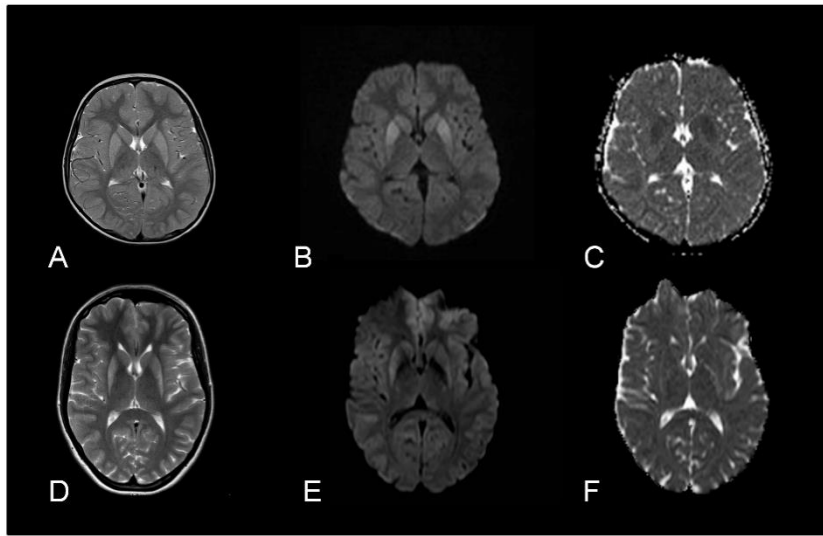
MRI features associated with dominant PDE10A mutations. Axial MR images of case 1 (A-C) and 2 (D-F). There is increased signal intensity within the striatum on T2-weighted images (A, D) and diffusion-weighted images (DWI) (B, E). In case 1, the putamen and caudate nucleus appear slightly swollen (A) and high signal on DWI (B) is confirmed to represent abnormal restricted diffusion on the ADC map (C). In case 2, the abnormal signal is principally located in the postero-lateral putamina, which also appear atrophic (D). There is no corresponding restriction of diffusion on the ADC map (F), and appearances suggest a more chronic disease stage.
